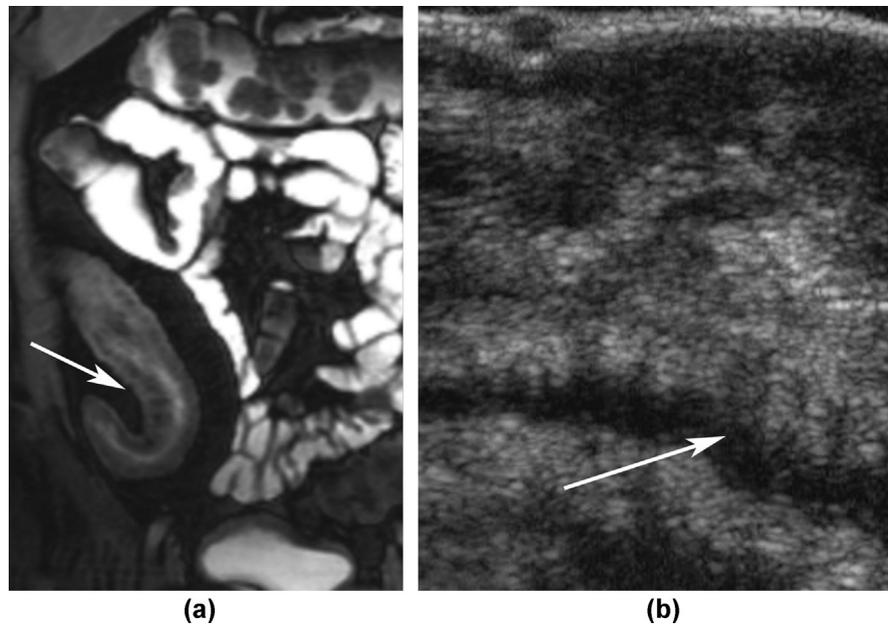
High resolution True-FISP images from MRE examinations in recurrent disease. (a) Recurrent mucosal inflammation shows striped appearance of the submucosa. (b) Similar appearance is seen on ultrasonography as hypoechoic linear streaks (arrow) within the echogenic submucosal layer.
